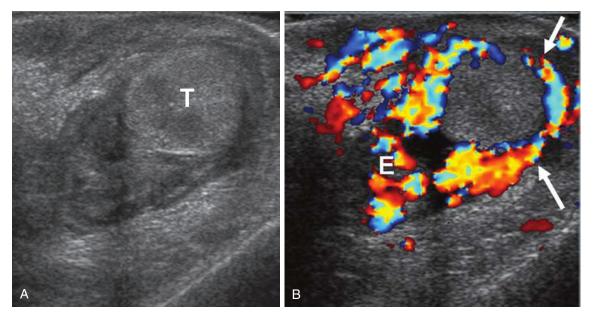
Testicular torsion. A, The left testis (T) is enlarged and hypoechoic. B, Color flow Doppler fails to demonstrate flow to the center of the testis. Exuberant flow is present around the testis (arrows) and the epididymis (E).
